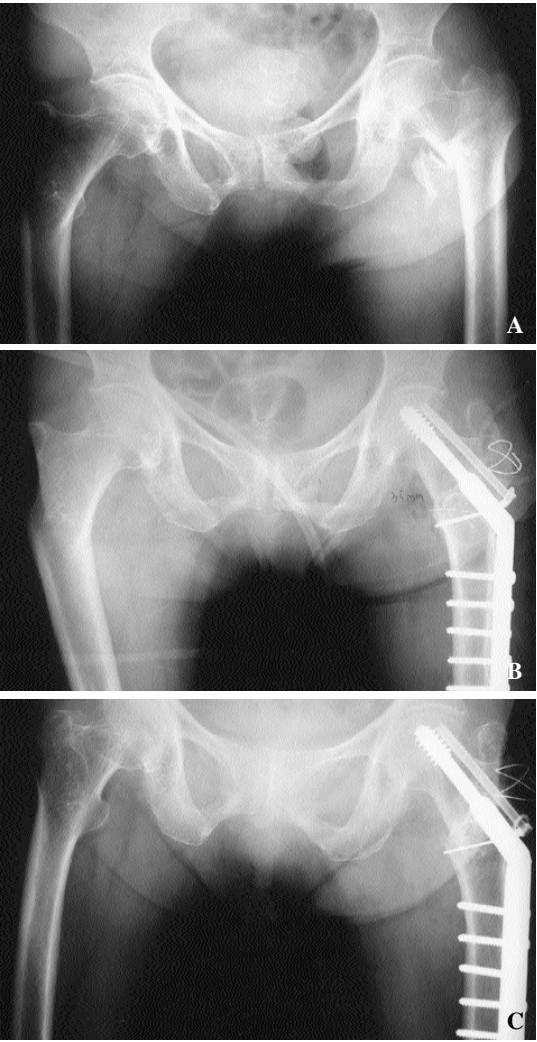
Serial radiograph of 69 year old woman treated with a compression hip screw. A. Evans unstable intertrochanteric fracture. Preoperative radiograph. B. Immediated postoperative radiograph. C. Postoperative 4 years after operation. The radiograph showed union of the fracture site. We obtained satisfactory result.
